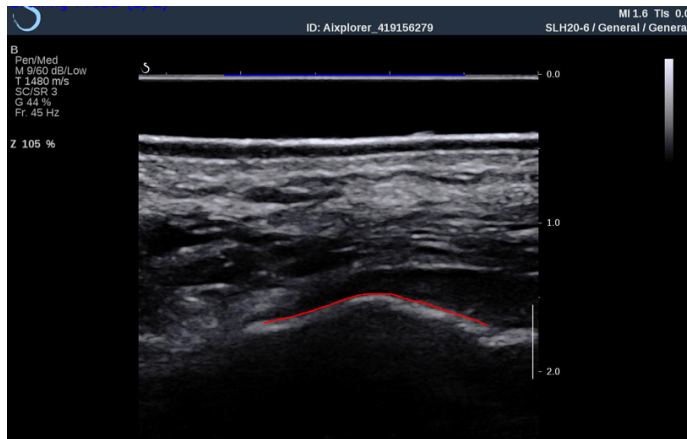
Labeled ultrasound image of the heel with the calcaneus (red) and probe (blue) labeled.
